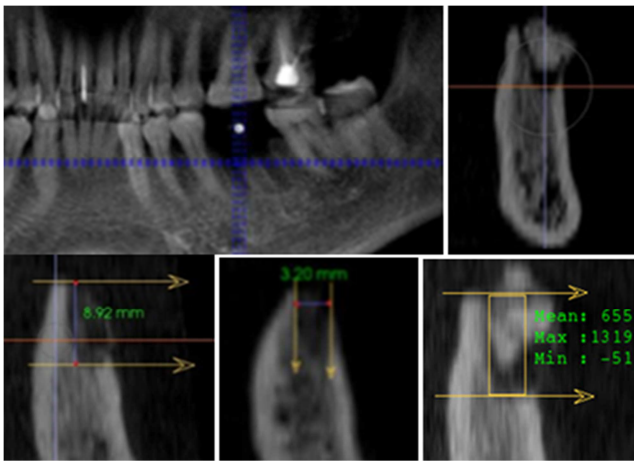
Radiographic parameters measurements.
